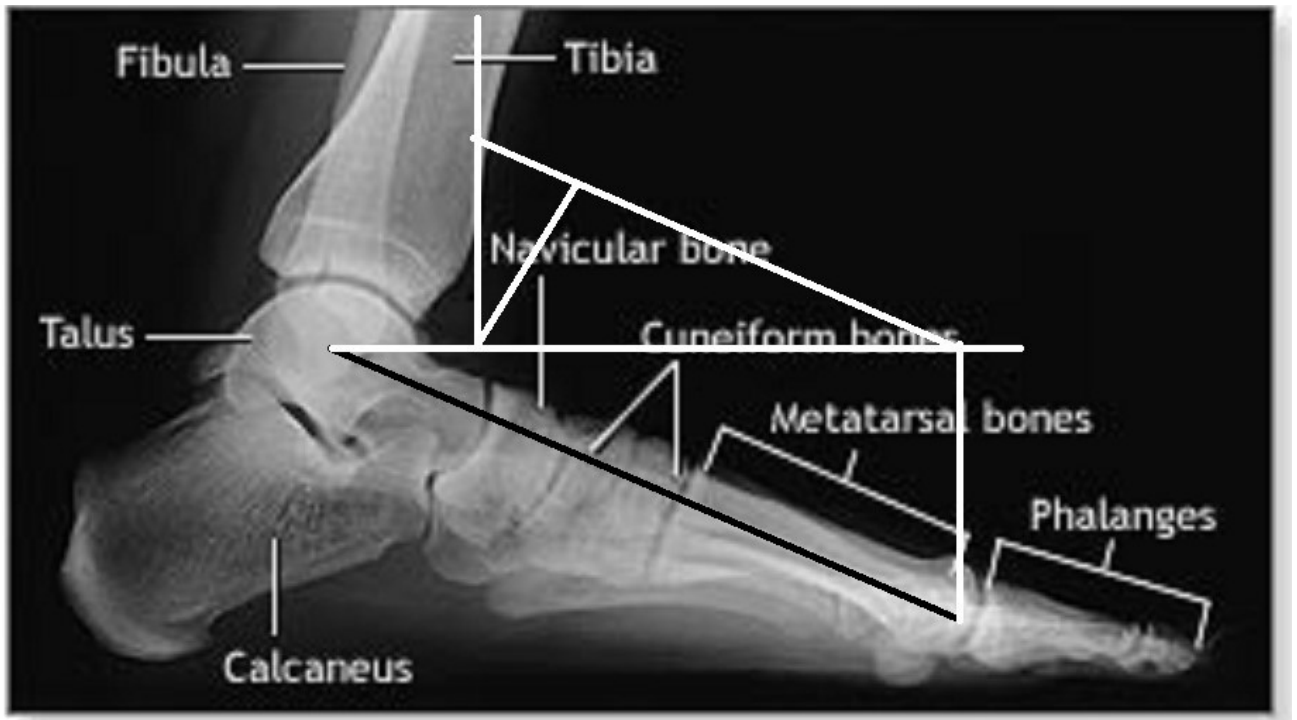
Foot X-ray showing the vectors of forces.
